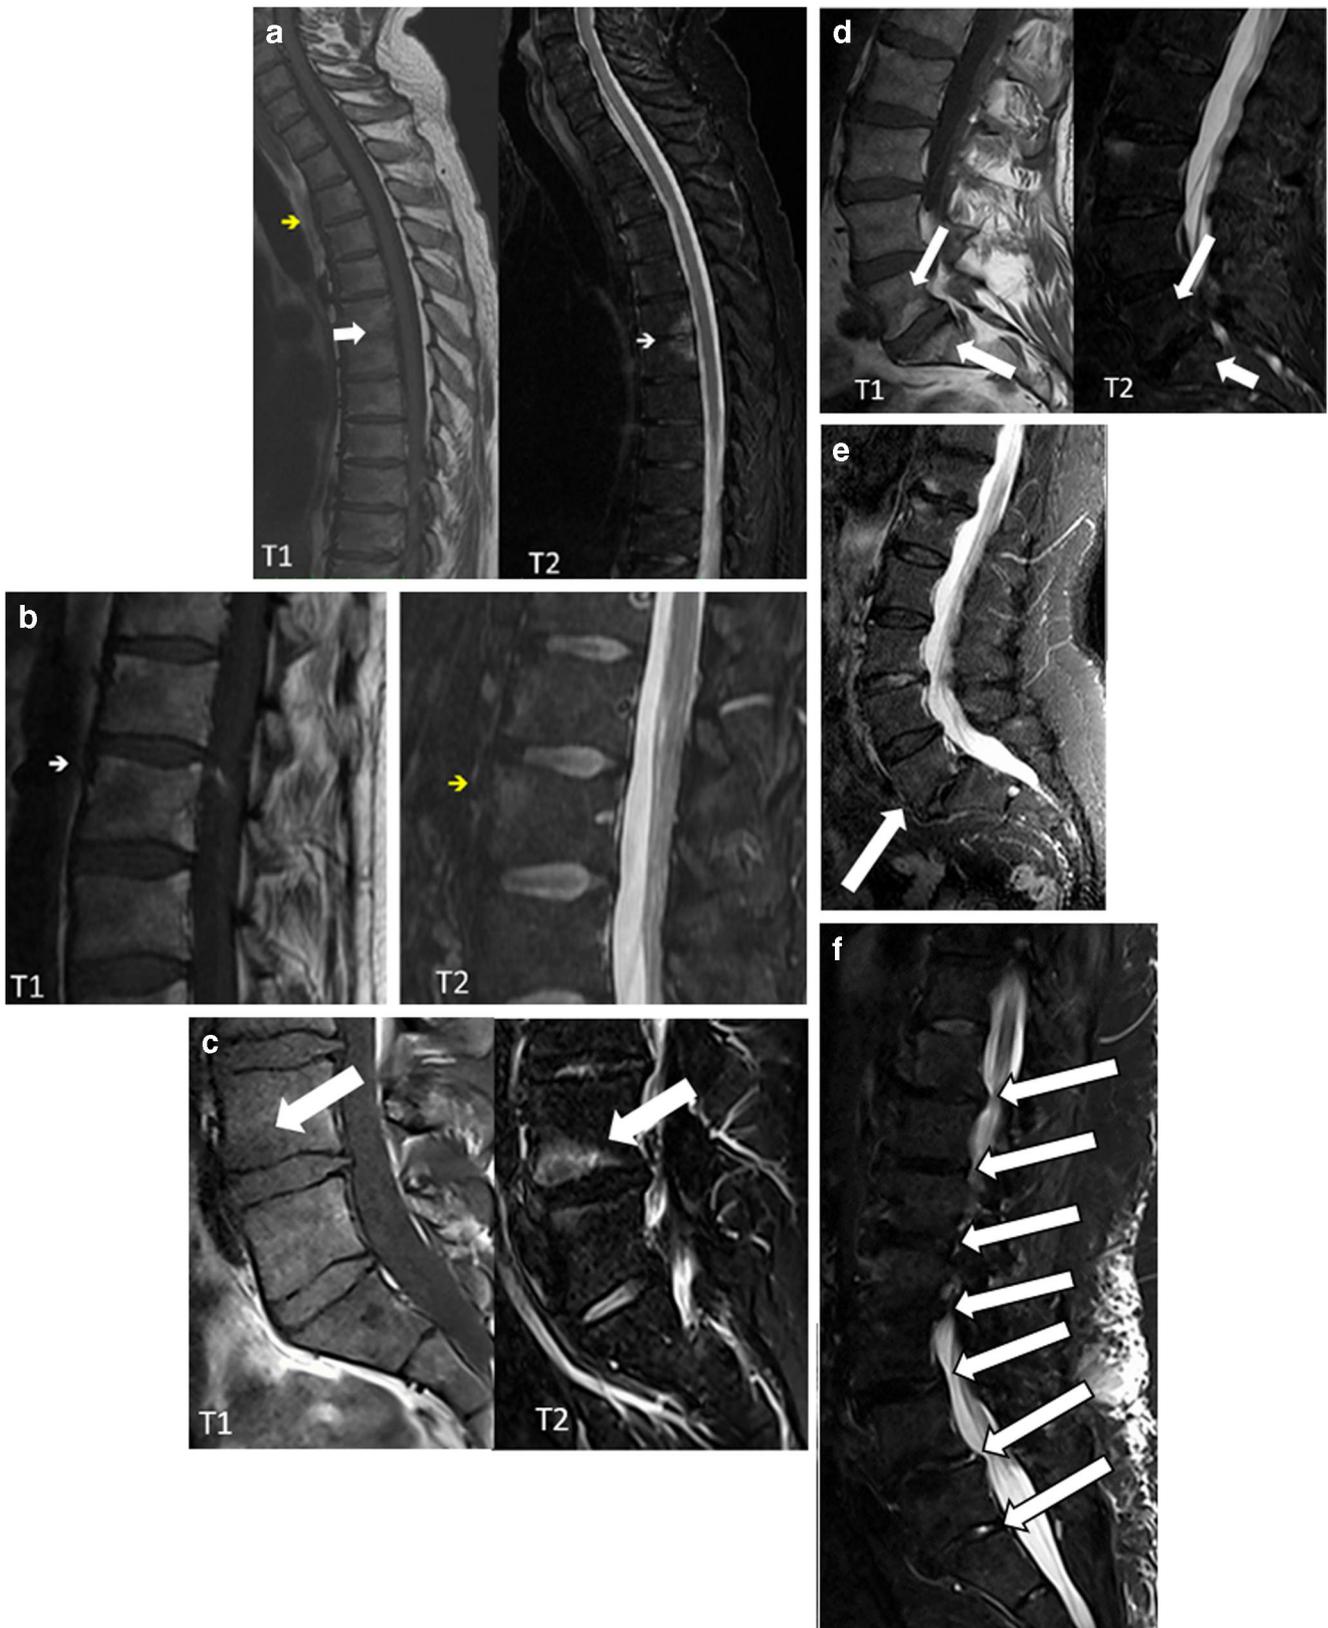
Inflammatory and structural anterior arch abnormalities on MRI T1- and T2-fat sat sequences. a Inflammatory vertebral corner (T1 and STIR) (axial spondyloarthritis patient). b Fatty vertebral corner (T1 and STIR) (axial spondyloarthritis patient). c Modic I (inflammatory) (A: T1;
